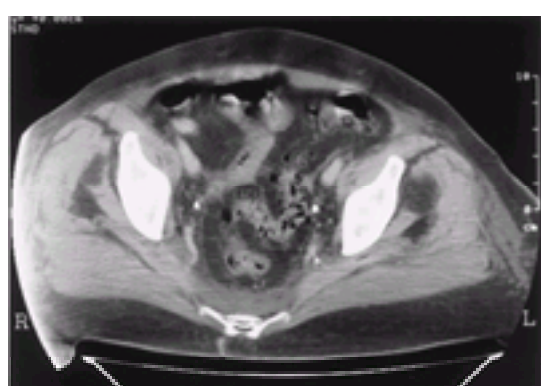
CT scan showing diverticula in the sigmoid colon
